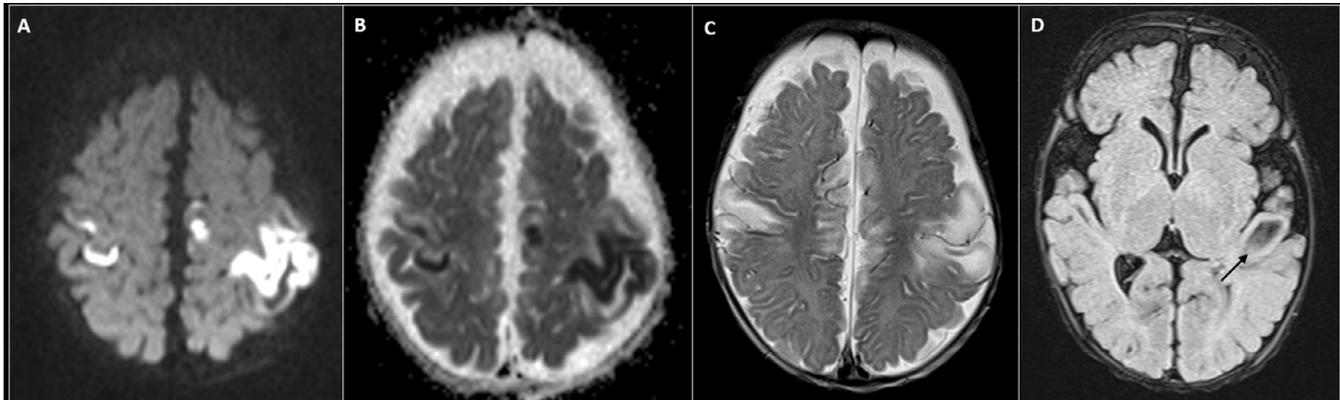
Diffusion-weighted imaging (DWI; b -factor, 1000 s/mm^2) of Patient 1 shows bilateral asymmetrical restricted diffusion associated with cytotoxic oedema in the perirolandic cortices (trace image, A, and apparent diffusion coefficient map, B). An axial T2-weighted image reveals hyperintense signal changes in the bilateral fronto-parietal cortico-subcortical regions (C). A fluid-attenuated inversion recovery (FLAIR) image demonstrates a subcortical cystic encephalomalacia (arrow) in the left superior temporal gyrus (D).
